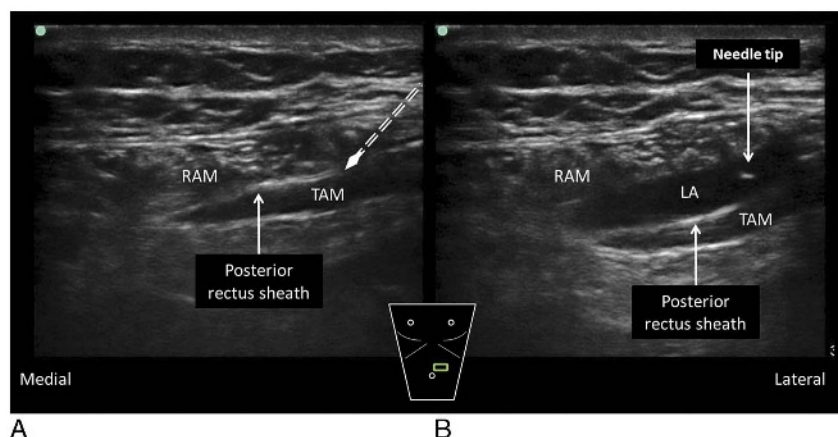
Ultrasound-guided rectus sheath block. A, Preinjection image. The probe is placed in a transverse orientation superior to the umbilicus to visualize the lateral aspect of the RAM and rectus sheath. The needle is inserted deep to the lateral edge of RAM but does not penetrate the posterior rectus sheath. B, Postinjection image. Injection here creates a pocket of LA between the RAM and the posterior rectus sheath. LA indicates local anesthetic. Reproduced with permission from KJ Chin Medicine Professional Corporation.
